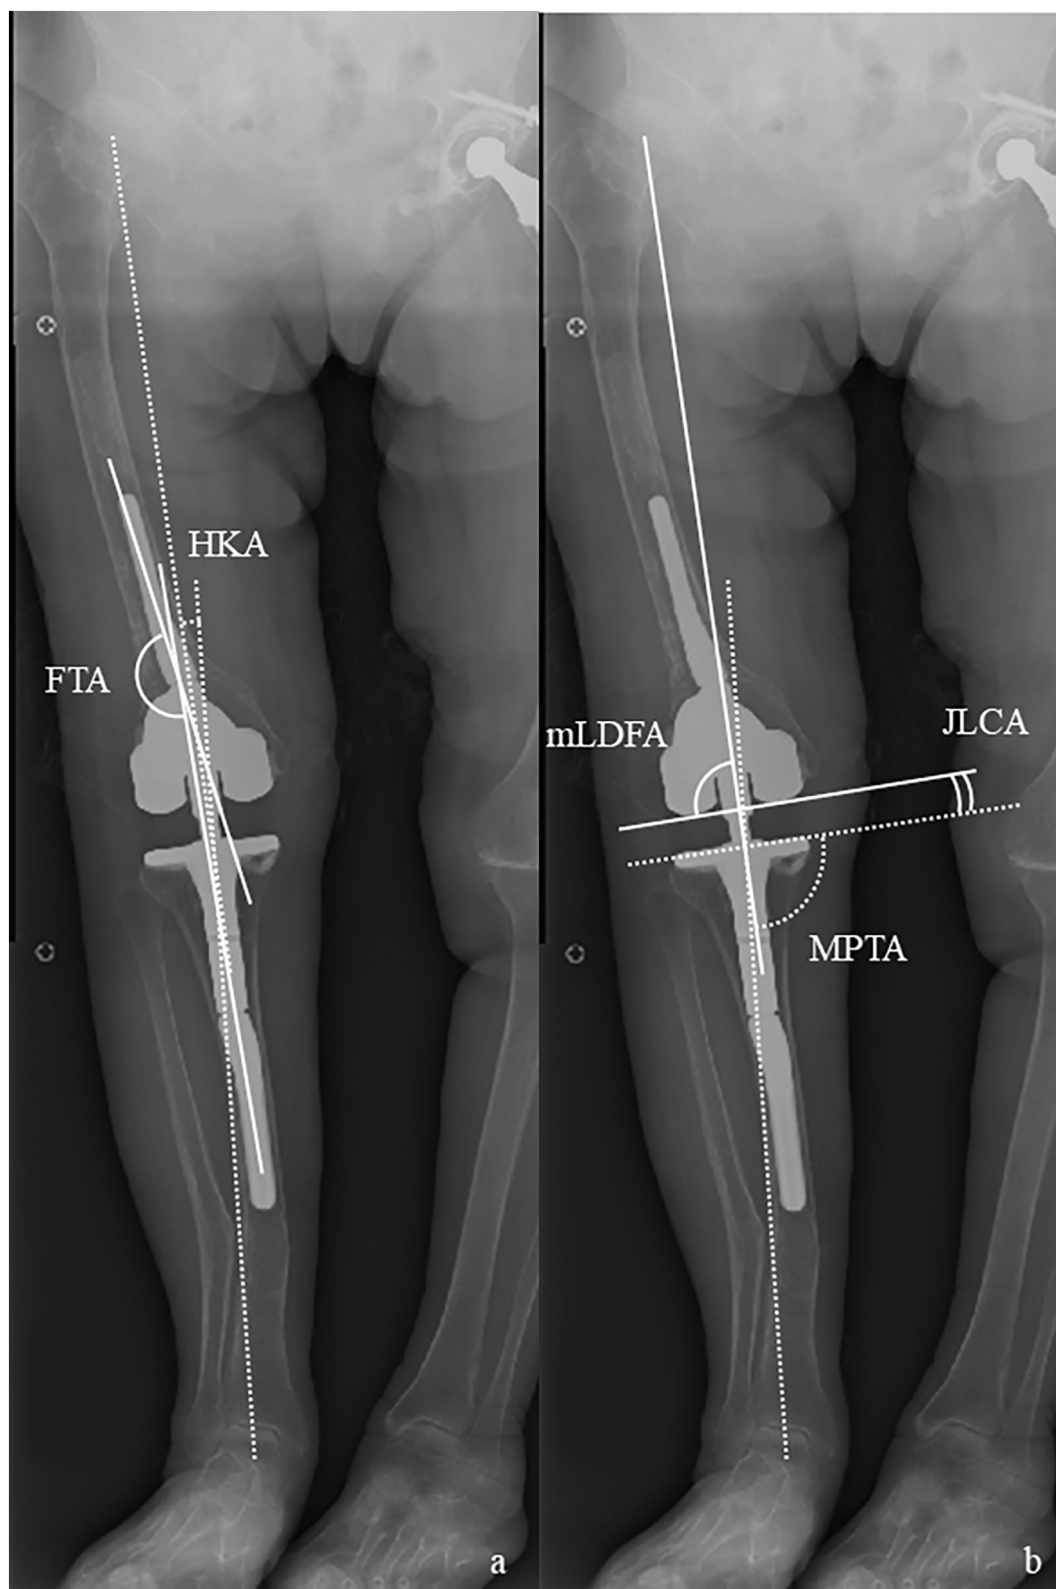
Postoperative long leg standing radiograph.
